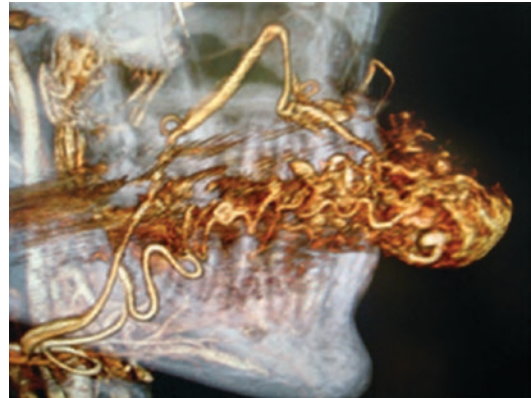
3D CT angiographic volumetric rendering of upper lip AVM
